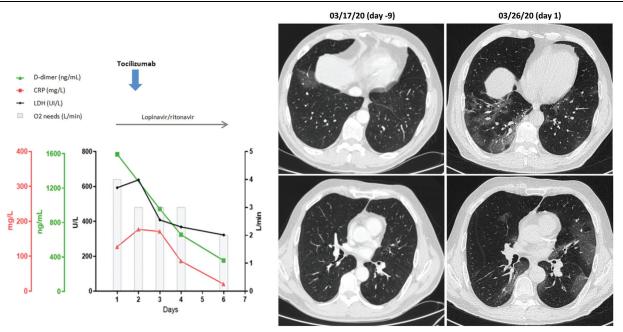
Trend of inflammatory indexes, O2 needs and chest computed tomography scan.
